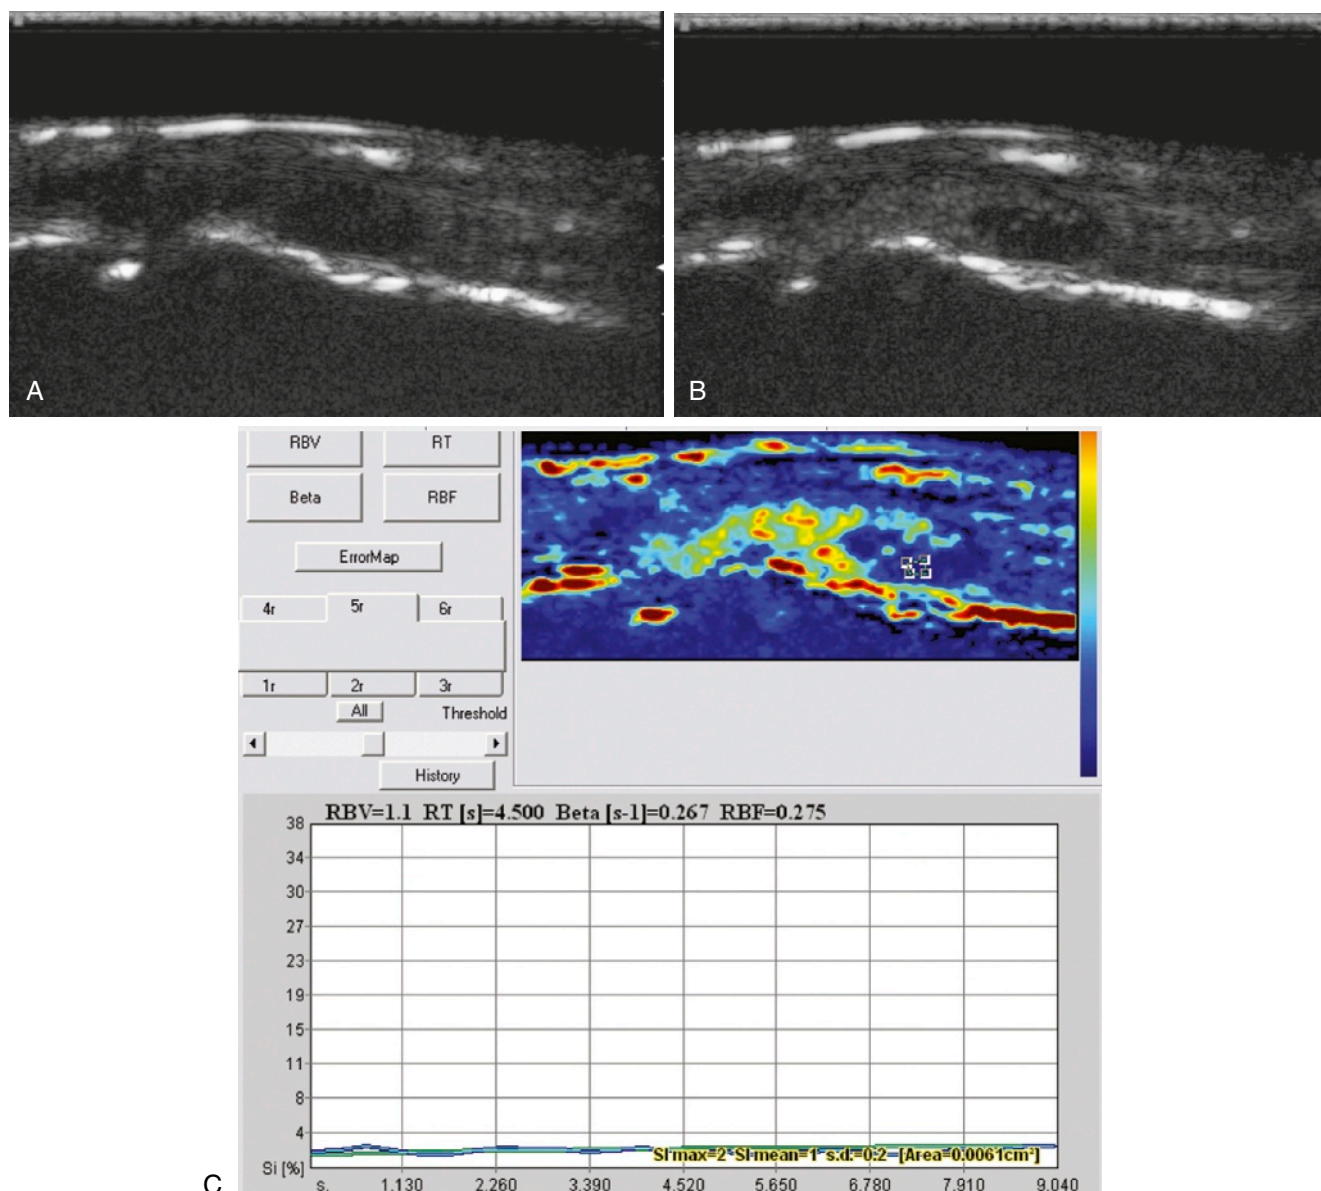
Scan of patient with early rheumatoid arthritis in clinical remission (not shown) did not show intra-articular power Doppler signals. Dorsal longitudinal scans of a metacarpophalangeal joint before (A) and after (B) contrast administration show gray-scale enhancement (white dots) in the hypoechoic thickening, corresponding to a subjective grading of grade 2. Ultrasound contrast administration enables differentiation of active synovitis from inactive effusion. C-E, Objective quantification with parametric maps enables quantitative perfusion parameters during a selected set of frames with simultaneous assessment of perfusion properties over the entire selected region. C, The curve of the outlined area (blue) shows low signal intensity (SI) increase because the placement of the region of interest (ROI) is in an inactive area (i.e., effusion) between the four rectangles. D, SI increase over the whole area of intra-articular joint thickening. E, ROI placement in the active area outlined (yellow-red), with the highest SI increase.
